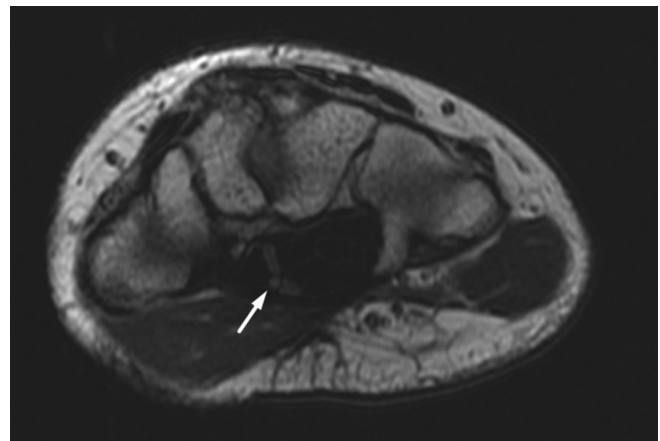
T2-weighted axial image displays persistent median artery (arrow) in carpal tunnel
